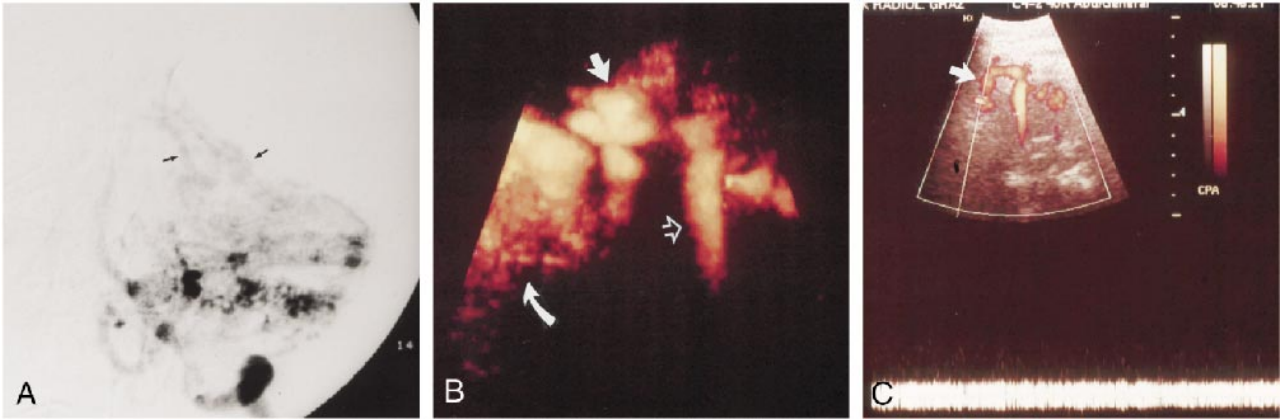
A, Medium-sized AVM involving the left cerebellar hemisphere. The lesion gets its arterial supply via the left posterior inferior cerebellar artery (PICA). Large draining veins are exhibited in the early angiographic phase (arrows). B, Three-dimensional image of the lesion depicts the malformation filled with color signals (curved arrow). A tortuous and hypertrophic feeder (straight arrow), representing the enlarged PICA, emerges from the basilar artery (open arrow). C, Spectral Doppler samples reveal venous flow within a draining vessel adjacent to the PICA (arrow).
